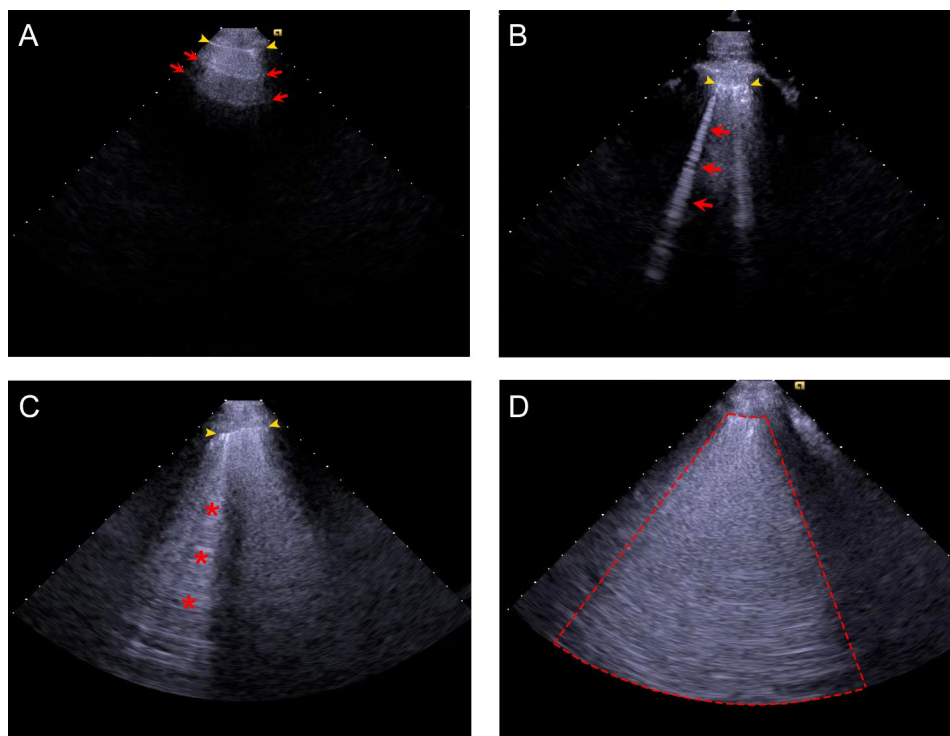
Typical lung ultrasound patterns. Normal pleural line (yellow arrowheads) and A-lines (red arrows) (Panel A); two separate B-lines (red arrows) and fragmented pleural line (yellow arrowheads) (Panel B); confluent B-lines (red asterisks) and blurred and irregular pleural line (yellow arrowheads) (Panel C); sonographic white lung (delineated with red dotted line) (Panel D)
